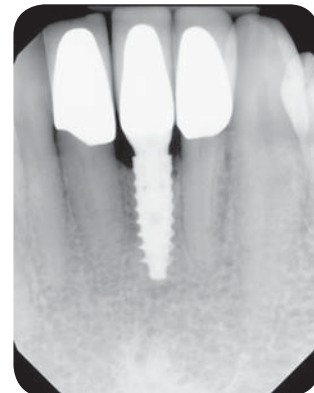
Radiograph of final implant placement.
